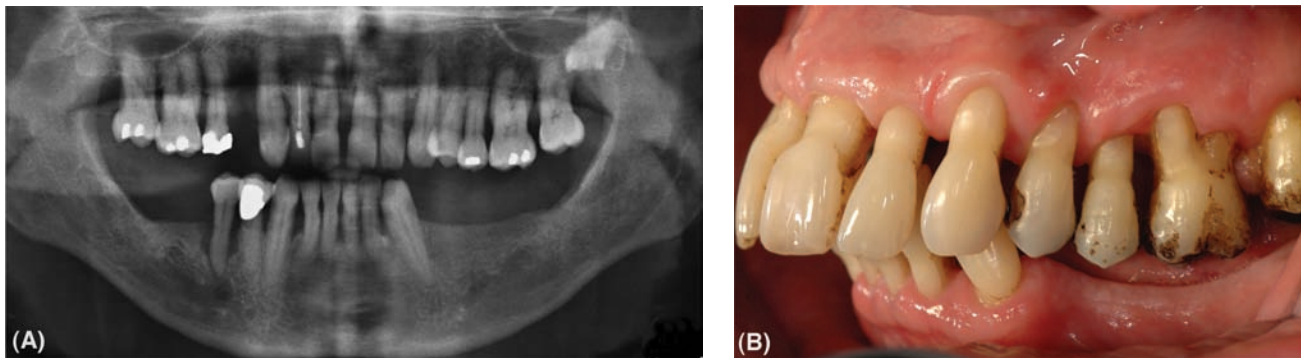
(A) Radiograph showing good bone height in the mandible. (B) However, the prognosis for the maxillary teeth may be poor. Loss of these teeth would put a different perspective on the management of the lower jaw.
